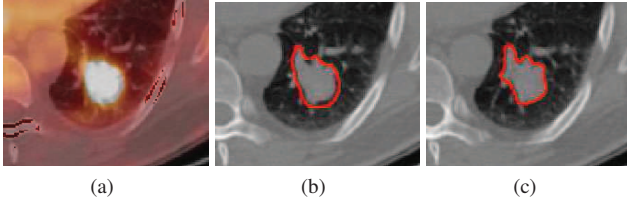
Averaging effect: (a) superimposed PET and CT images, (b) vectorial segmentation with fixed parameters, (c) segmentation with a spatially varying $\lambda(x)$.
